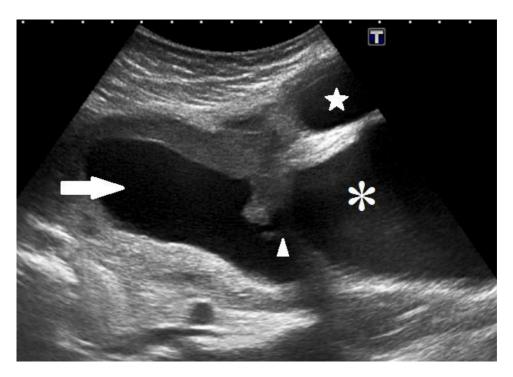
Gray-Scale Transabdominal Ultrasound Image showing distended endometrial cavity filled with anechoic fluid (arrow). Discontinuity of anterior wall of uterus (arrow head) demonstrating communication of uterine cavity with the urinary bladder (asterisk). Another anechoic fluid filled cavity (star) is noted antero-superior to urinary bladder in the anterior abdominal wall.
